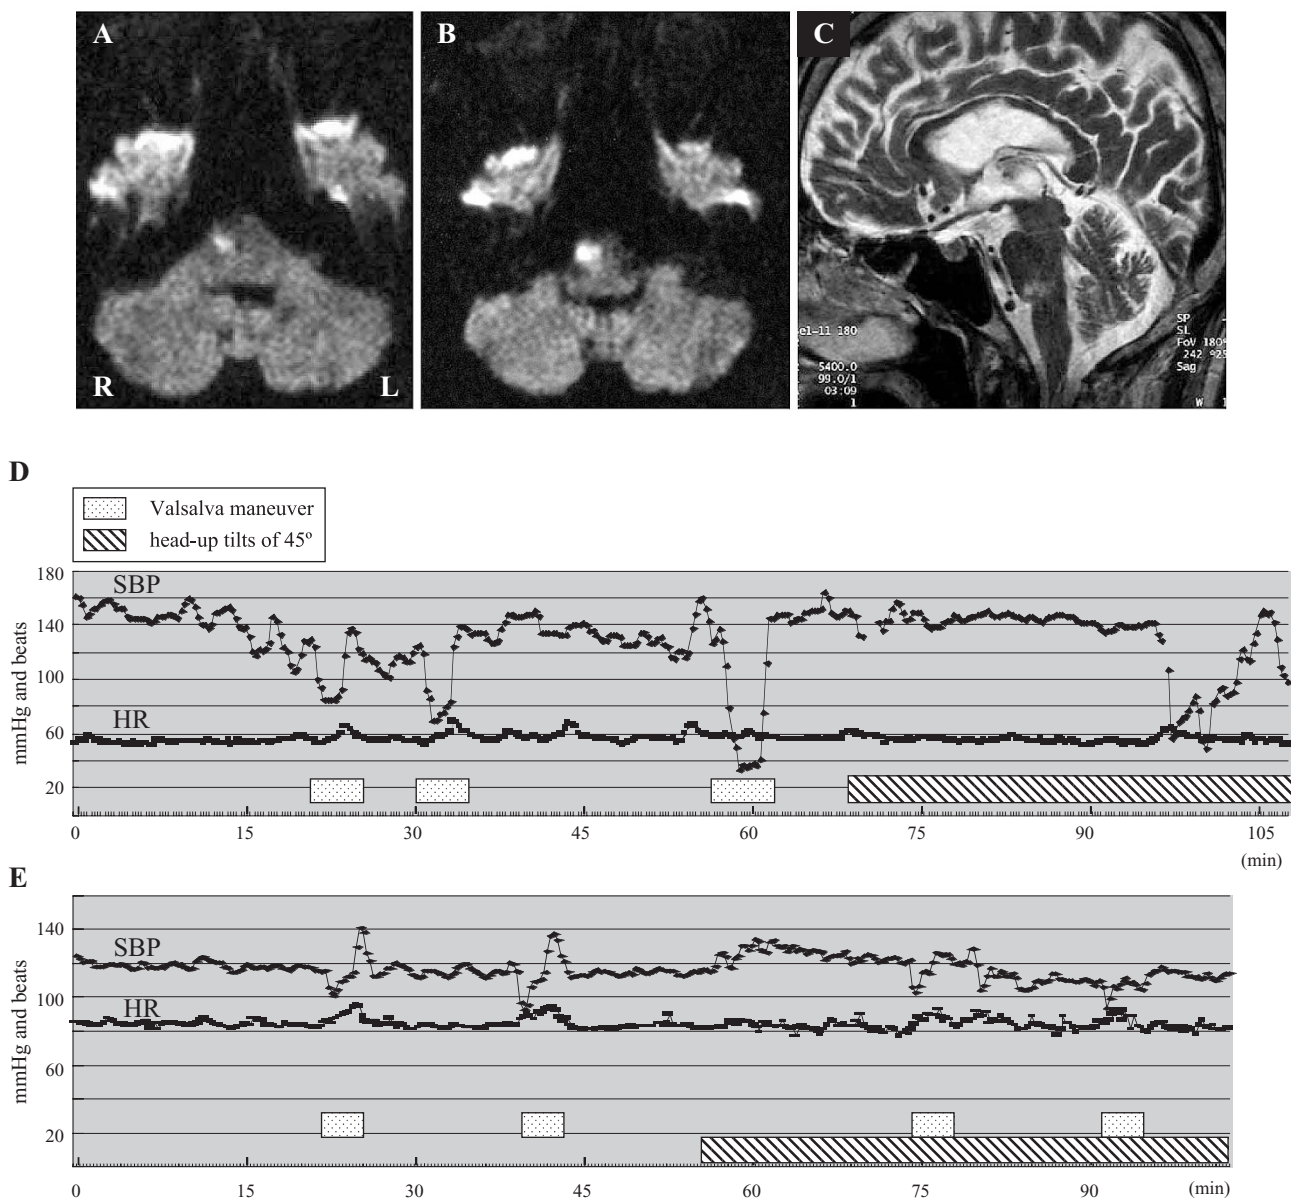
A–C: A pontomedullary infarct on MRI. Diffusion-weighted image (b value=1,000) on day 1 shows high intensity in the pontomedullary junction including or adjacent to the rostral ventrolateral medulla (A), which can be seen to have expanded dorsally on day 16 (B: diffusion-weighted image; C: T₂-weighted image). D, E: Changes in systolic blood pressure (SBP) and heart rate (HR). On day 14 (D), severe hypotension with a 60-mmHg drop in SBP was recorded during the Valsalva maneuver and during 30-min head-up tilts of 45°. On day 40 (E), the SBP drop during the Valsalva maneuver or head-up tilts was less (<20 mmHg). The HR can be seen to have increased from ~60 beats/min on day 14 to ~80 beats/min on day 40.
